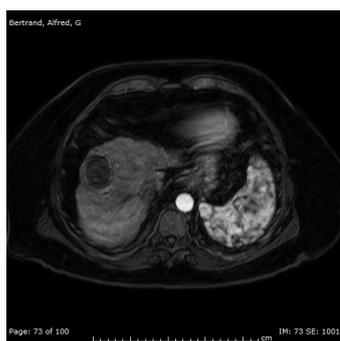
Arterial phase contrast-enhanced MRI one month after second DEB-TACE. There is no residual enhancing tumor tissue, consistent with a complete imaging response by mRECIST criteria.
